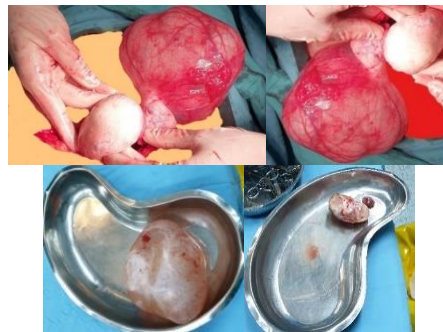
Large, heavy cystic neoplasms and torsioned paraovarian mass around tube with negative Doppler negative and unclear content teratoma and hemorrhagic cyst in the left.
